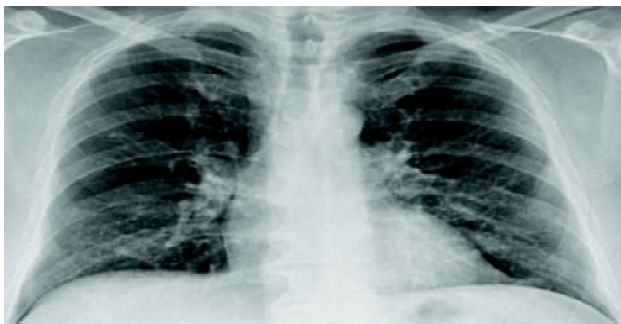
Chest X-ray showing no significant abnormality with resolution (Case 3) after plasma therapy.
